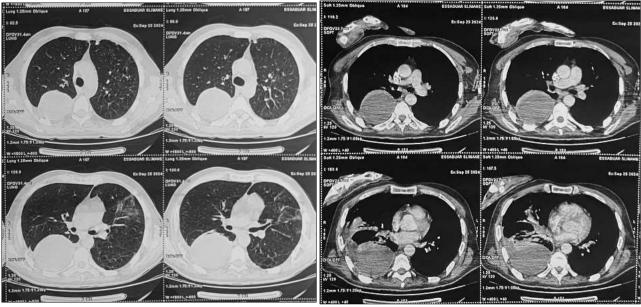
Follow-up thoracic CT showing resolution of the pyopneumothorax.
